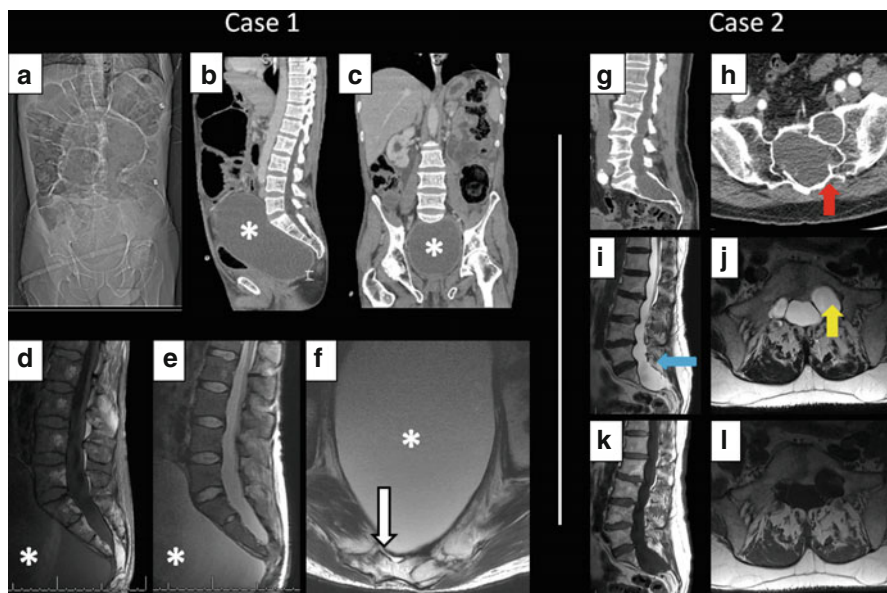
Case 1. A 45 year old ‘Marfanoid’ man presents with a painful, distended abdomen. Plain radiographs (a) confirm acute large bowel obstruction. He proceeded to CT scanning (b sagittal reconstructed & c coronal reconstructed) which identifies a large cystic mass within the pelvis, thinned sacral bone and a possible defect in the anterior sacrum. This is further characterised by MRI (d sagittal T1-weighted, e sagittal T2-weighted, f axial T2-weighted through the level S3) which confirms a diagnosis of anterior meningocele (*), filling via an antero-lateral ectatic defect at S3 (white arrow on f). He was managed conservatively and went on to make a full recovery. Case 2. A 36 year old Ghent positive MFS patient presents to clinic with chronic back pain with no radiculopathy, neurological deficit or reported headaches. Sagittal reconstructed CT (g) and axial images (h) identify a widened lumbosacral canal (S1 > L5), thinning of the sacral laminae (red arrow) and enlarged sacral foraminae. Subsequent MR imaging (i sagittal T2-weighted, j axial T2-weighted, k sagittal T1-weighted, l axial T1-weighted) confirms the diagnosis of dural ectasia (blue arrow) with nerve root enlargement (yellow arrow) with early signs of lateral meningocele. As a result the body of the sacrum is severely thinned due to remodelling around the expanded theca. Some disc and facet degeneration is also observed as well as ‘scalloping’ of the posterior vertebral bodies at other levels. She was successfully treated with oral analgesia and a course of physiotherapy
